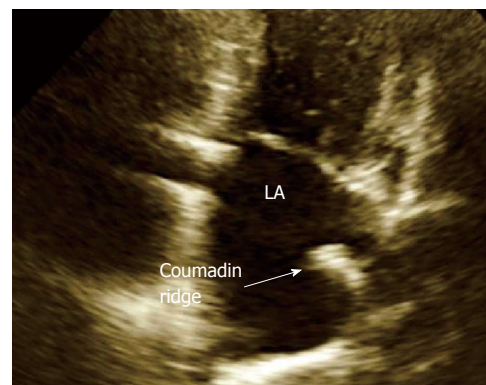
Apical four-chamber transthoracic echocardiography view of coumadin ridge in the left atrium. LA: Left atrium.
